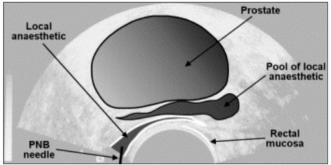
local anaesthetic infiltration under ultrasound guidance.
